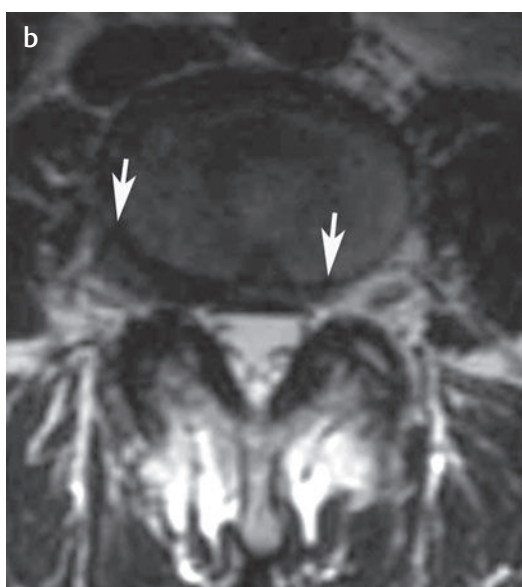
Lumbar disc bulge. (a) Sagittal and (b) axial T2-weighted images show a right paracentral disc bulge that is asymmetric to the right, with extension into the right lateral recess and far laterally at the L4-L5 level (at arrow on a and between arrows on b).[†]
